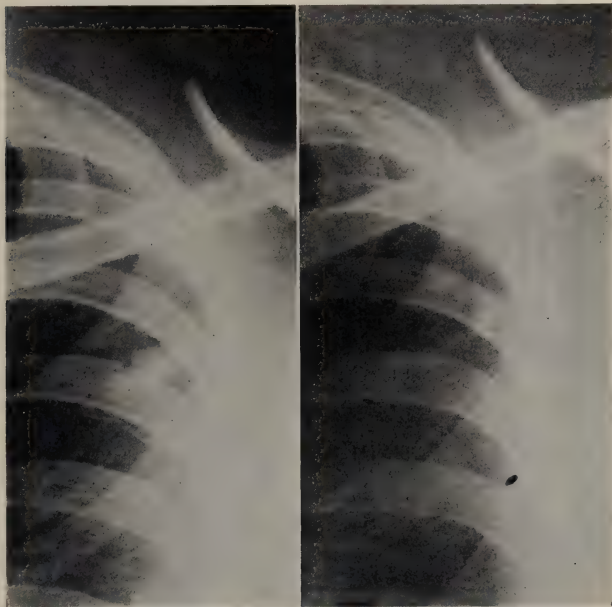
(Case 7). A (Left). Roentgenogram showing soft infiltration in the first and second spaces and behind the second rib on the left side near the axilla.
